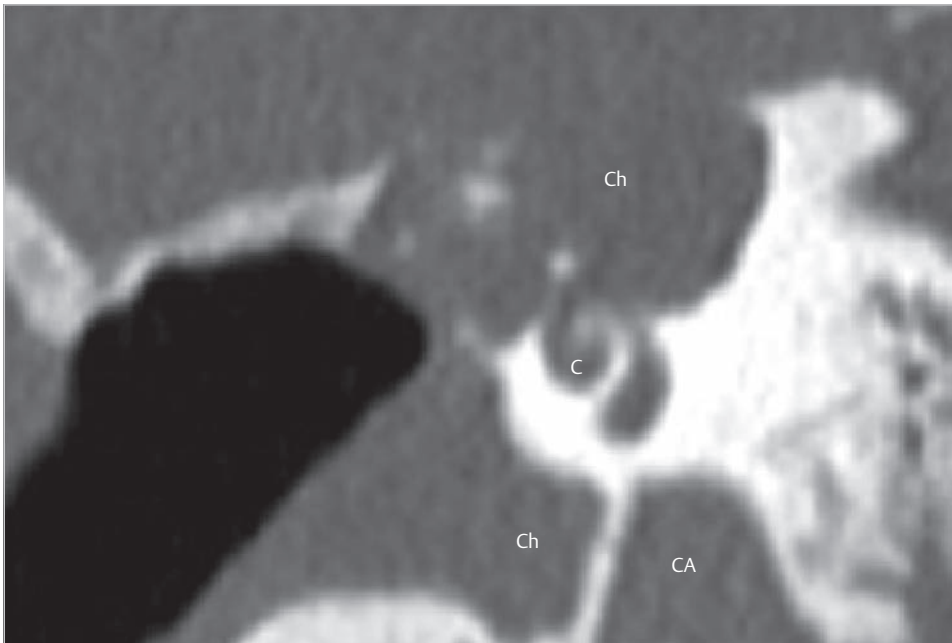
The coronal CT shows heavy erosion of the cochlea and extensive exposure of the middle fossa dura. The geniculate ganglion and the labyrinthine segment of the facial nerve are totally engulfed by cholesteatoma. The tympanic cavity is filled with soft tissue, and hypotympanic cells are eroded suggesting presence of cholesteatoma also in the hypotympanum. C, cochlea; CA, carotid artery; Ch, cholesteatoma.
